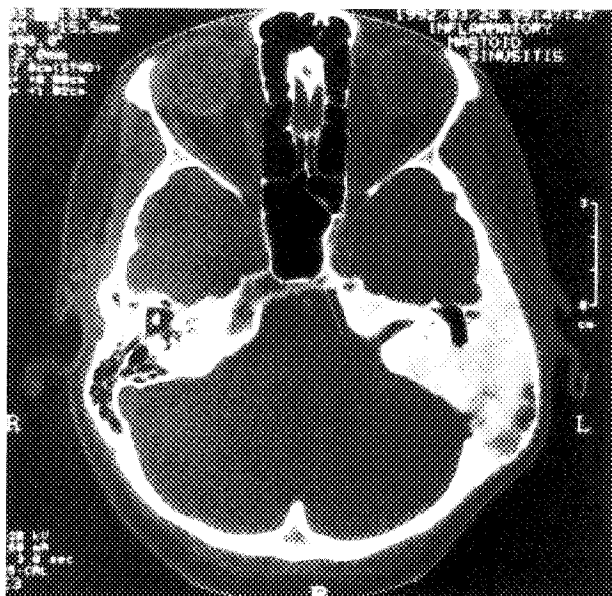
Axial CT scan (case 3) of Pagetoid fibrous dysplasia replacing confines of left temporal bone with preservation of otic capsule structures. Note ground-glass appearance of lesion secondary to a mixture of fibrous and bony elements.
